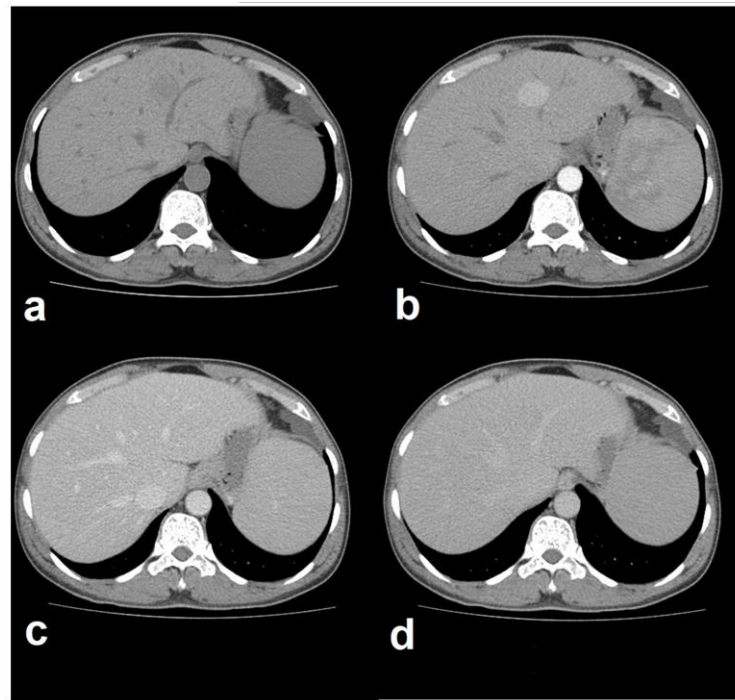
Computed tomography scans showing a 2.2×3.0×2.8-cm well-defined hypodense lesion with arterial enhancing lesion and faint wash-out in the delayed phase at segment IVa of the left hepatic lobe. Plain (a), arterial phase (b), portovenous phase (c), and delayed phase (d).
